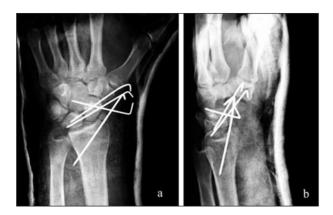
Post-operative x-ray. A: Anteroposterior view; B: Lateral view.
